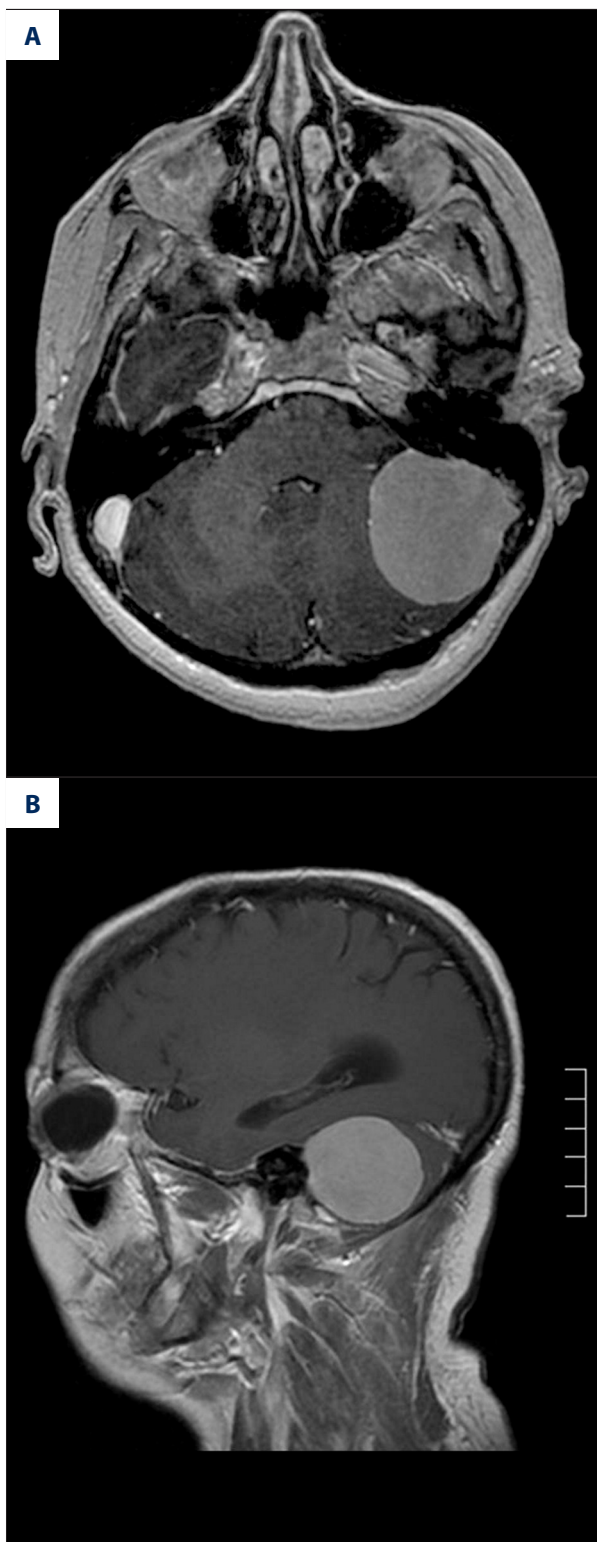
Preoperative axial (A), sagittal (B), and coronal (C) magnetic resonance imaging (MRI) scans with contrast showing a mass lesion in the left cerebellopontine angle entering the left sigmoid sinus.
